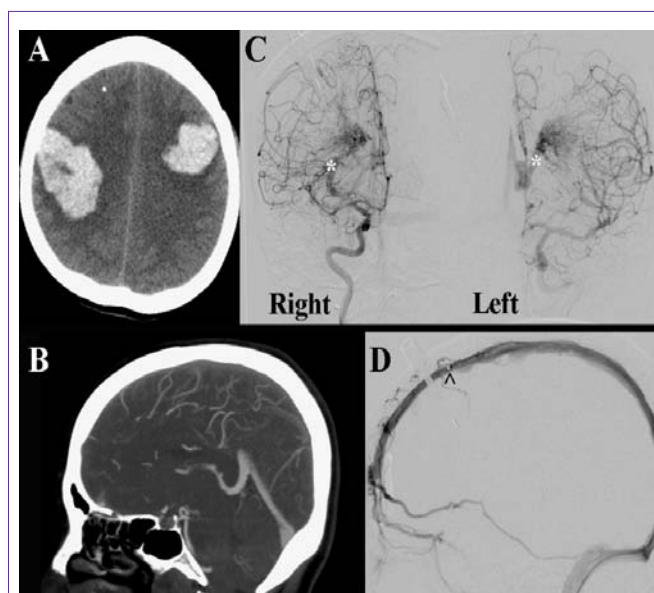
A) Bilateral hemorrhages suspicious for venous occlusion (axial CT) B) Absence of sagittal sinus filling (CTV). C) ICA injections demonstrating bilateral thalamic AVM with high flow features. (*ectatic venous drainage with arterial phase) D) Sagittal sinus patency as demonstrated by venous catheter (^ shows distal tines of catheter).
